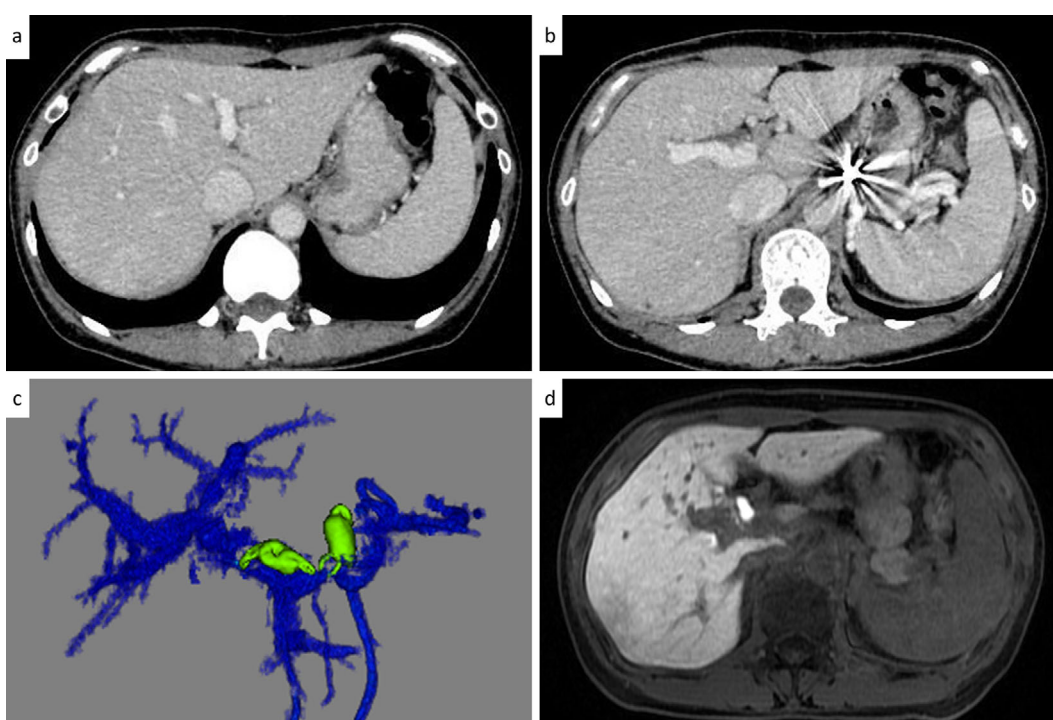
Abdominal CT and MRI findings after balloon-occluded retrograde transvenous obliteration (B-RTO). (a, b) Axial CT images after B-RTO showed development of intra- and extrahepatic portal veins. (c) Three-dimensional computed tomography imaging showed intra- and extrahepatic portal vein development. The coils were placed on the left and post gastric veins, shown in the image, and the shunt vessel disappeared completely at 6 months after B-RTO. (d) Gd-EOB-DTPA enhanced MRI at 6 months after B-RTO showed complete regression of multiple FNA-like lesions in the hepatobiliary phase.
